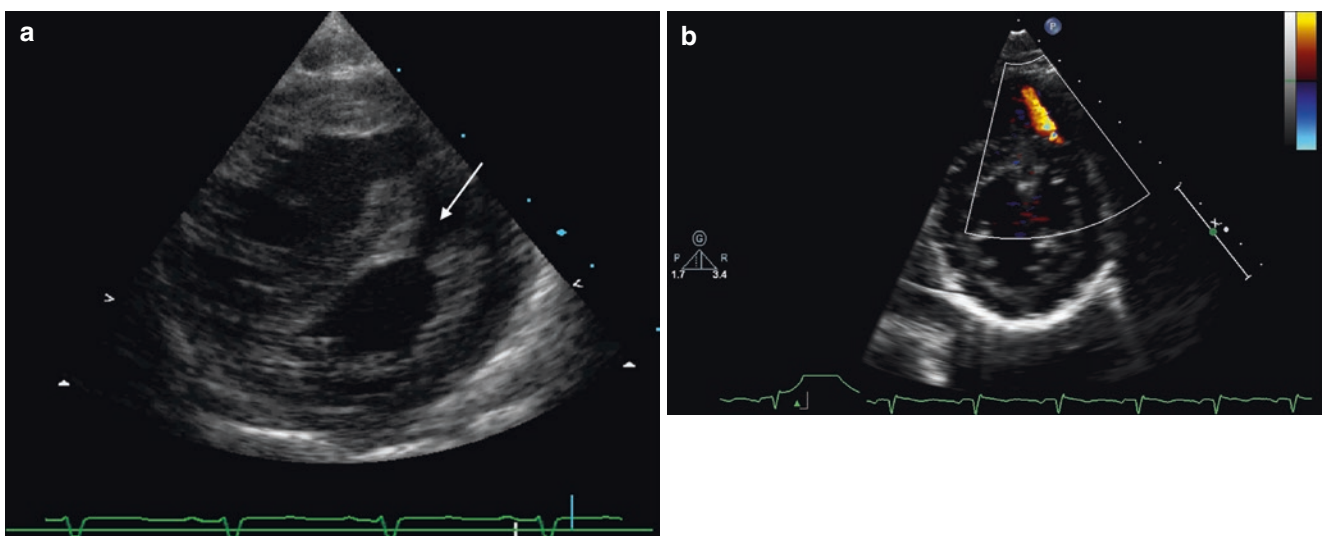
Large anterior muscular VSD (arrow) in the parasternal short-axis view (a); colour Doppler in the same plane shows LR-shunting in a patient with a small restrictive defect (b)
